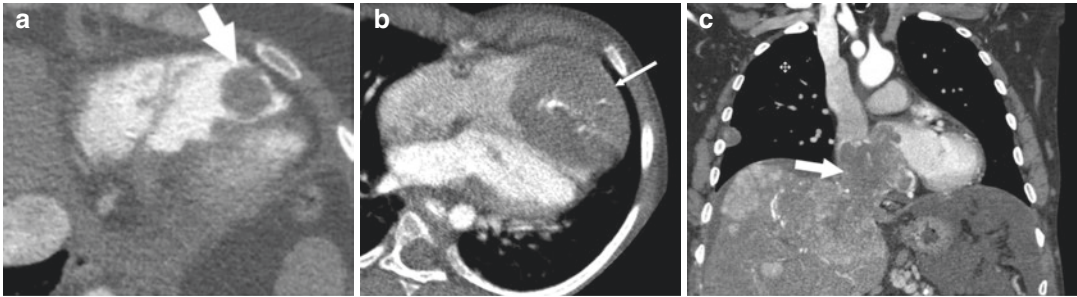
Masses. (a) Axial contrast enhanced CTA shows a large thrombus (arrow) in the right ventricle. (b) 4-chamber CT in another patient shows a large mass containing central calcification (arrow), which was proven to
